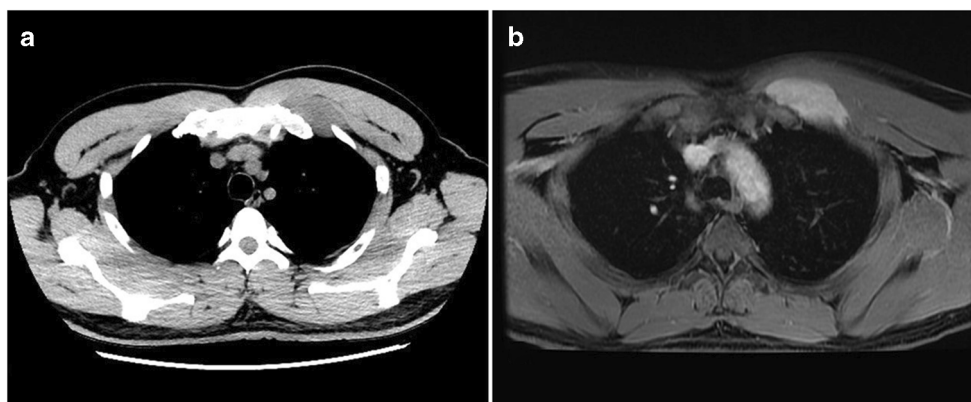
a CT chest (mediastinal window) showing a well-defined slightly hypodense soft tissue lesion (5.5 × 5.7 × 2.5 cm) located at the anterior chest wall deep to the left pectoralis muscle at the left infra-clavicular region lying on the anterior ends and left sternocostal joint of the first two left ribs. b MRI chest (T2-weighted image) showing a mass lesion (5.9 ×
